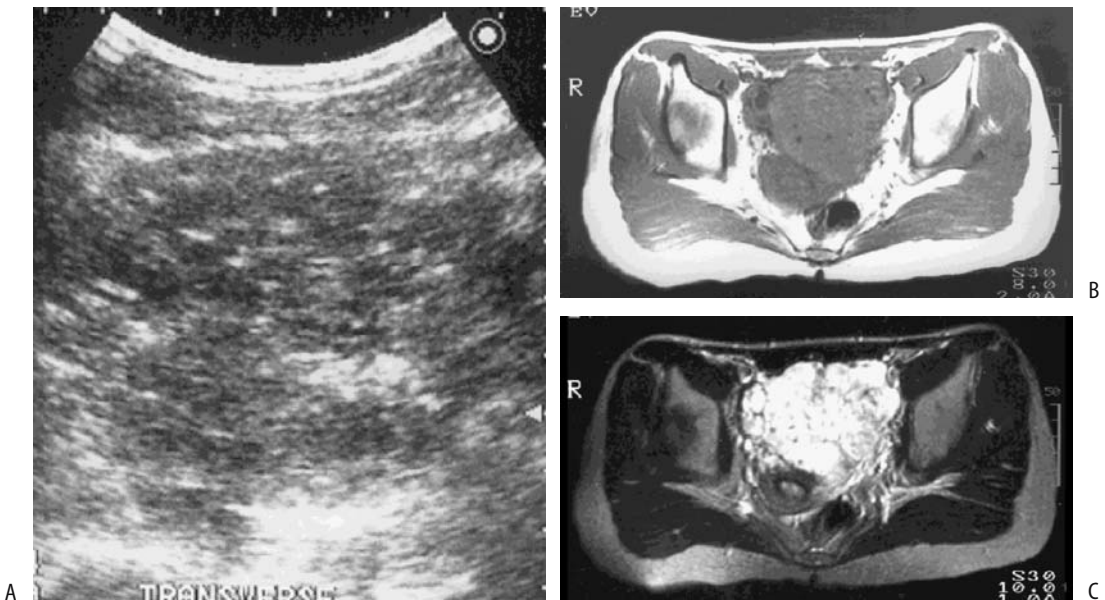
Uterine cavernous hemangioma. A: US reveals a pelvic tumor. Doppler (not shown) did not detect blood flow. T1- (B) and T2- (C) weighted MR images confirms a pelvic tumor which was located posterior to the bladder. (Courtesy of Takao Kobayashi, M.D., Shinshu University, Nagano prefecture, Japan.)
